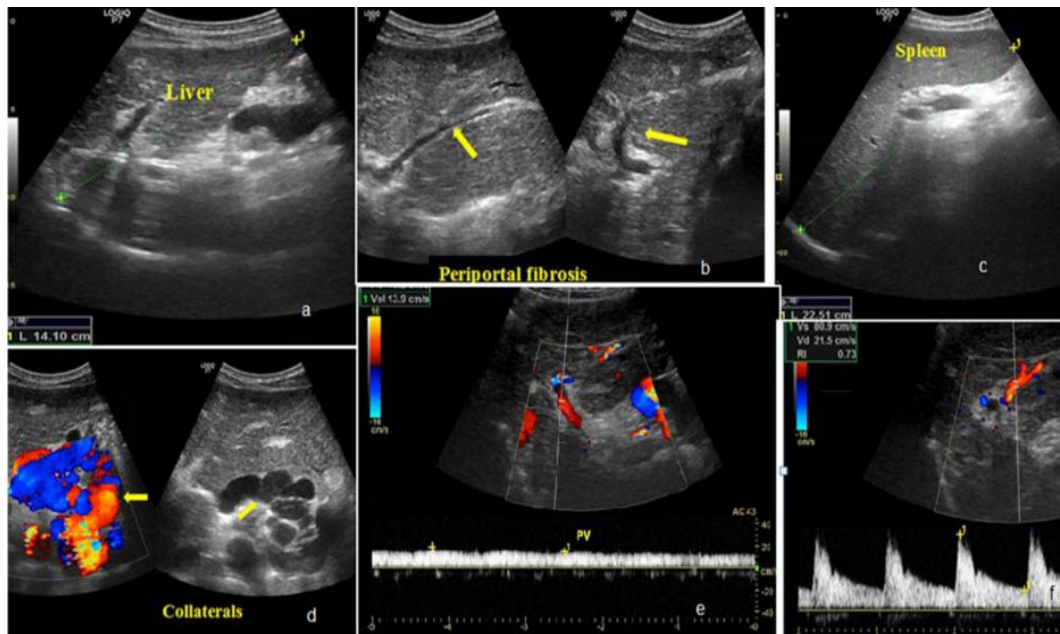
Ultrasound Doppler of cirrhotic liver (63)
